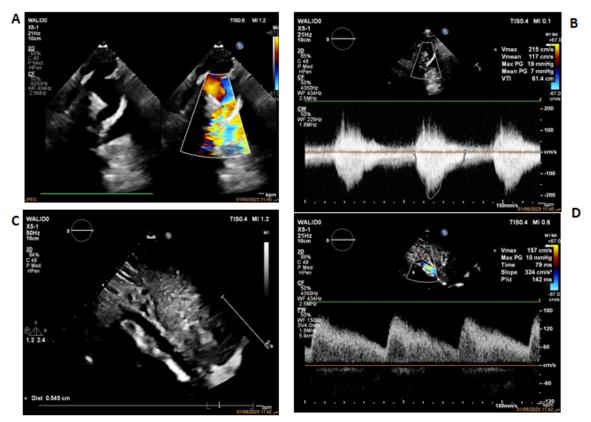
A+B: suprasternal aortic arch 2-D echocardiogram with color flow Doppler: a left-sided aortic arch with an isthmic gradient of approximately 7 mmHg and a caliber of 8 mm., C+D: abdominal 2-D echocardiogram: weakly pulsatile abdominal aorta with diastolic run-off and calibers ranging from 4 to 7 mm in the entire abdominal aorta.
